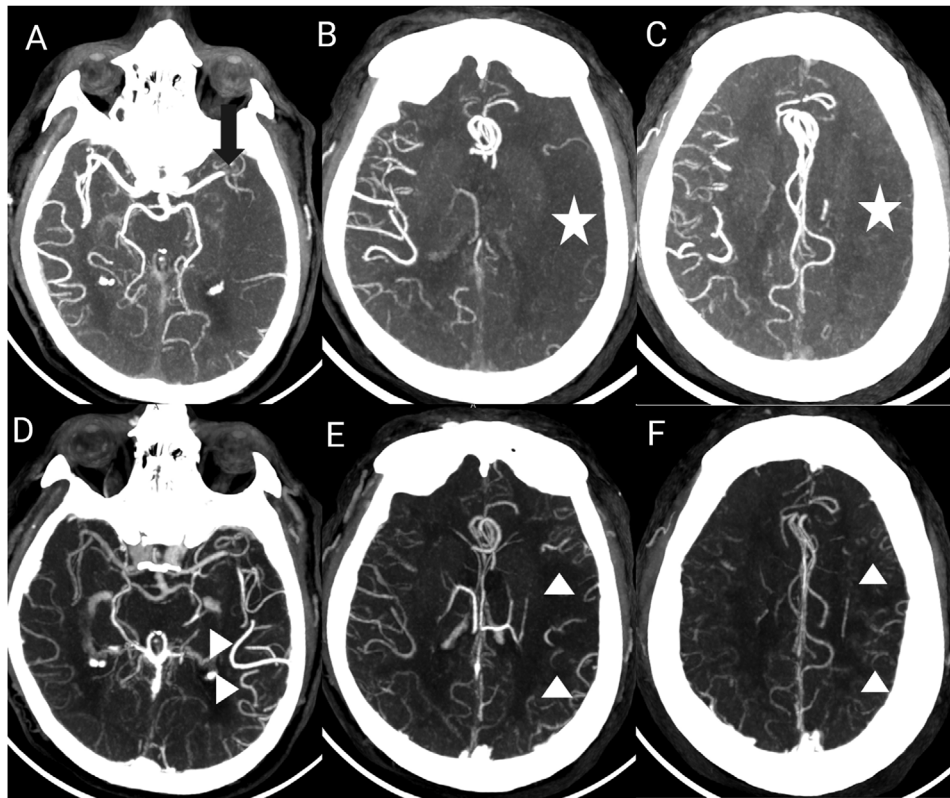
A 68-year-old male presented with an acute onset of right-sided hemiplegia and expressive and receptive aphasia, with a symptom onset time of 4.5 h prior to arrival. (A–C) Axial images of maximum intensity projection (MIP) of the arterial phase of multiphase CT angiography (m-CTA) showing an abrupt cutoff in the distal part of the M1 segment of the left middle cerebral artery (black arrow in A) and significant paucity of the distal left middle cerebral artery branches with a large area of hypoperfusion in panels B and C, respectively (represented by the “star”). (D–F) Axial images of MIP of the venous phase of m-CTA showing excellent reformation of the distal temporal branches of the left middle cerebral artery by the collaterals (arrowheads in D); however, significant paucity of the distal frontoparietal branches of the left middle cerebral artery is noted even in the venous phase (arrowheads in E and F).
